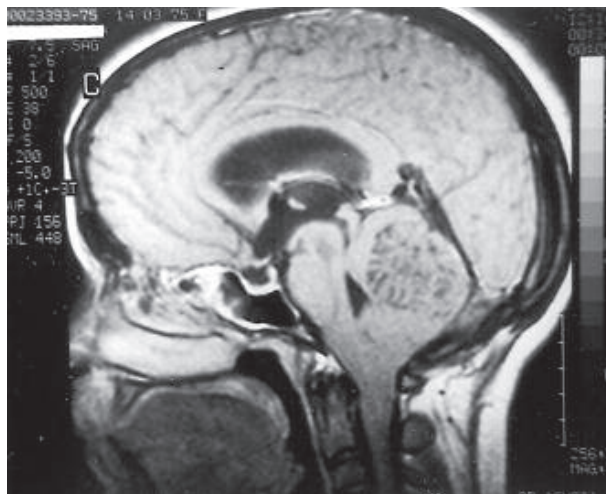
Sagittal T1-weighted image. Multiple enlarged folia forming a characteristic tiger-striped appearance, are evident. The vermis has expanded into the fourth ventricle and there is evident tonsillar herniation below the level of foramen magnum.
